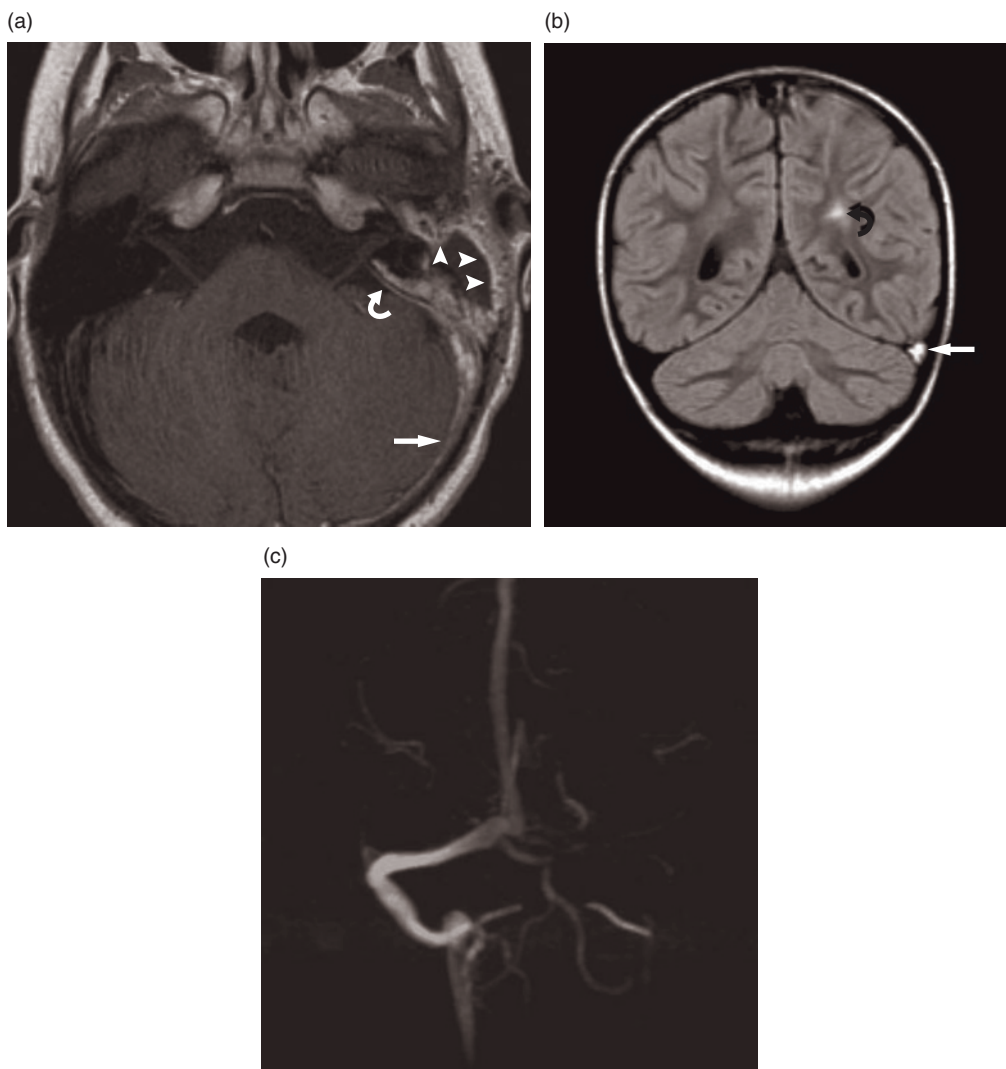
Intracranial complications of oto-mastoiditis. (a) Axial T1-weighted MR image with contrast. Enhancement of the wall of the petrous bone (arrowheads) and leptomeninges of the posterior fossa (curved arrow), suggesting inflammatory tissue and meningitis. Hyperintensity of the transverse sinus suggesting thrombosis (straight arrow). (b) Coronal FLAIR T2-weighted image. Sinus thrombosis (straight arrow) and cerebritis (curved arrow). (c) 2D-TOF MR angiography. Absence of blood flow into the left transverse sinus due to thrombosis.
